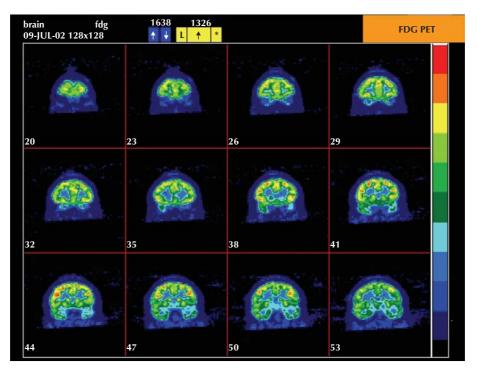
Brain FDG-PET coronal slices showing left temporal hypometabolism in the left temporal pole, mesial temporal structures and extending in to the lateral superior and middle lateral temporal lobe (slices 32-53 in the bottom two rows).
